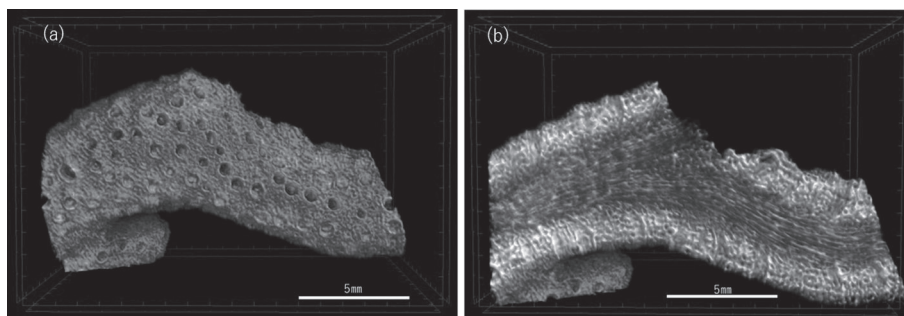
Microfocus X-ray computed tomography image of coral exoskeleton-derived bone replacement material. a: Coral exoskeleton, b: Cross section of coral exoskeleton
